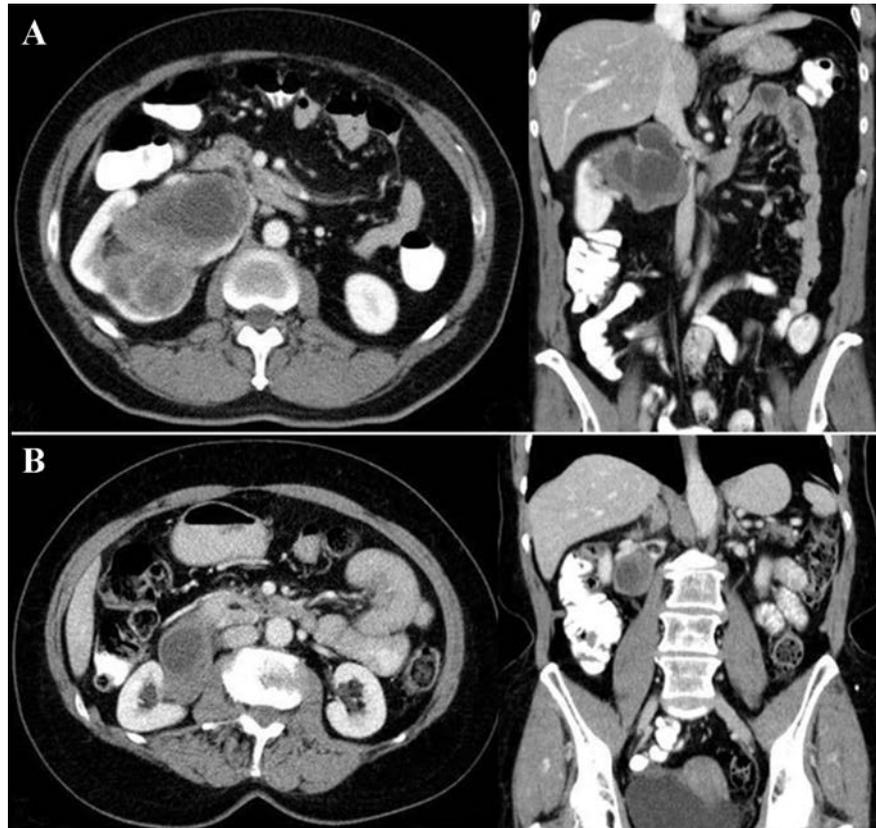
A) Computed tomography-scan showing a right renal mass with central hypodense areals, contrast enhancement and contact to the vena renalis and vena cava. B) Computed tomography-scan showing a 6.4×3.8 cm mass with origin of the renal hilum and contact to the vena cava.
